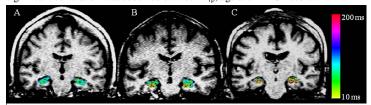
T_{1p} maps of the hippocampus region in the brain (in color) overlaid on fluidattenuated T₁₀ MRI of control (A), MCI (B) and AD patient (C). Pixels with higher
